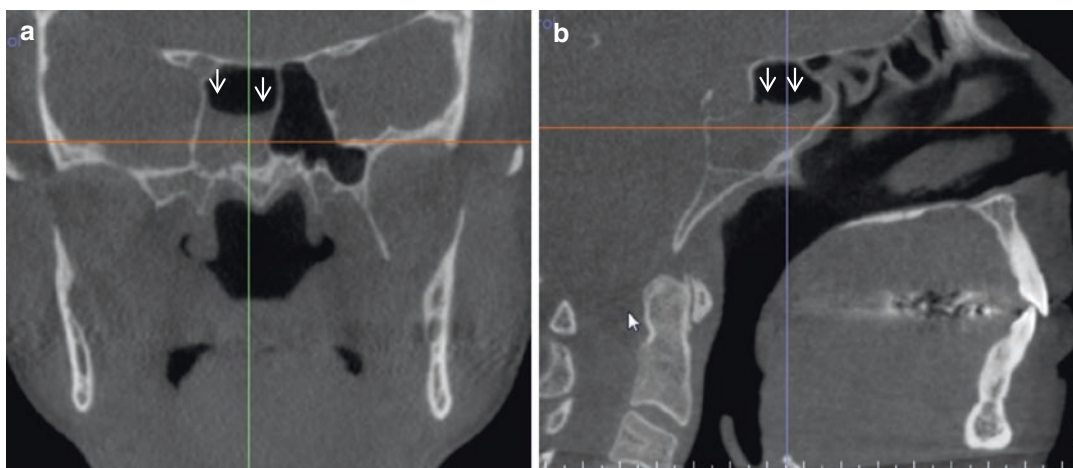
Axial (a), coronal (b), and sagittal (c) CBCT sections of the sphenoid sinuses showing almost complete opacification in the left sphenoid (arrows); consistent with sphenoid sinus inflammation
